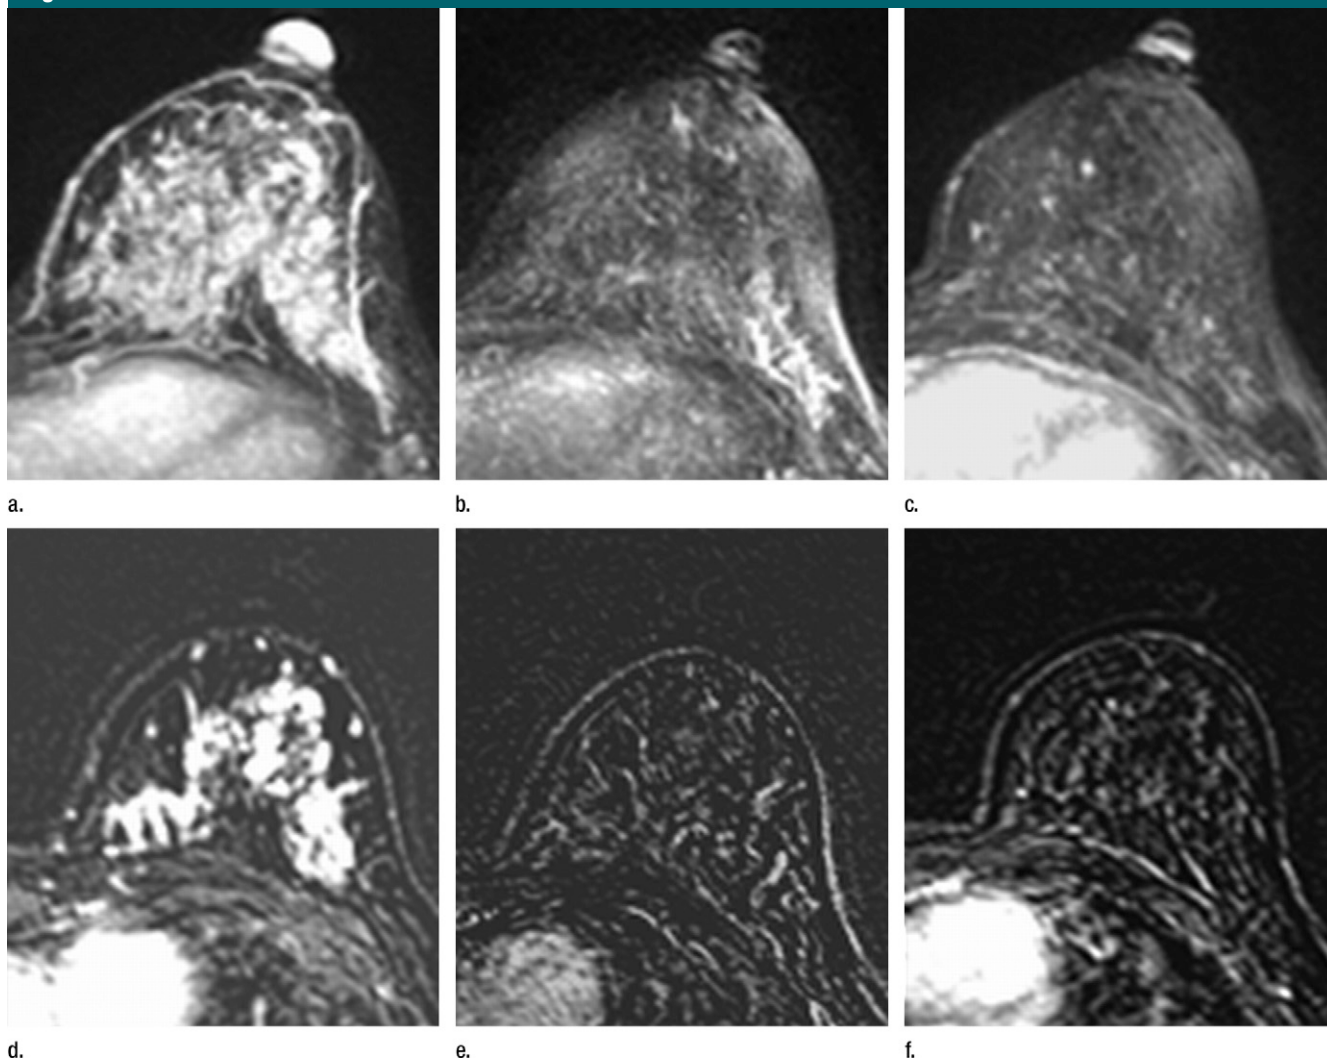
Axial (a–c) maximal intensity projection and (d–f) original subtraction MR images in 37-year-old woman with HER2-positive hormone receptor–negative cancer in left breast. (a, d) Baseline images obtained before NAC show approximately 8-cm lesion with diffuse, nonmasslike enhancement. On (b, e) images obtained during NAC, the tumor is reduced to a small area of faint enhancement, and on (c, f) images obtained after NAC, the tumor is barely visible. Clinical complete response was diagnosed on the basis of MR imaging findings. Final pathologic examination showed pCR.
